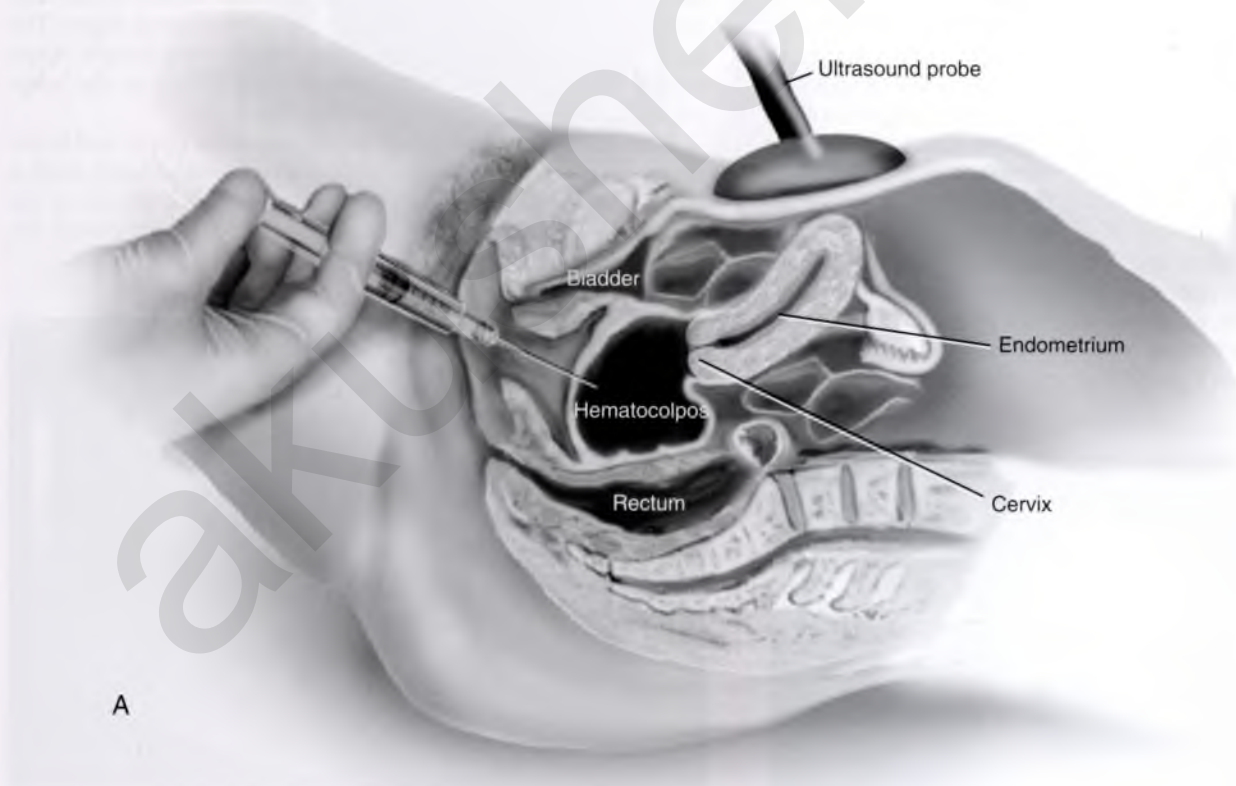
A. A needle is passed from the lower vagina into the hematocolpos under abdominal ultrasound guidance when the upper vagina cannot be identified after dissection.
